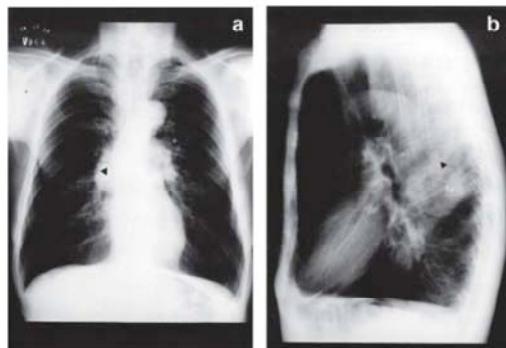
Frontal (a) and lateral (b) chest x-rays showing a spherical mass lesion (arrows), 5 cm in diameter.
